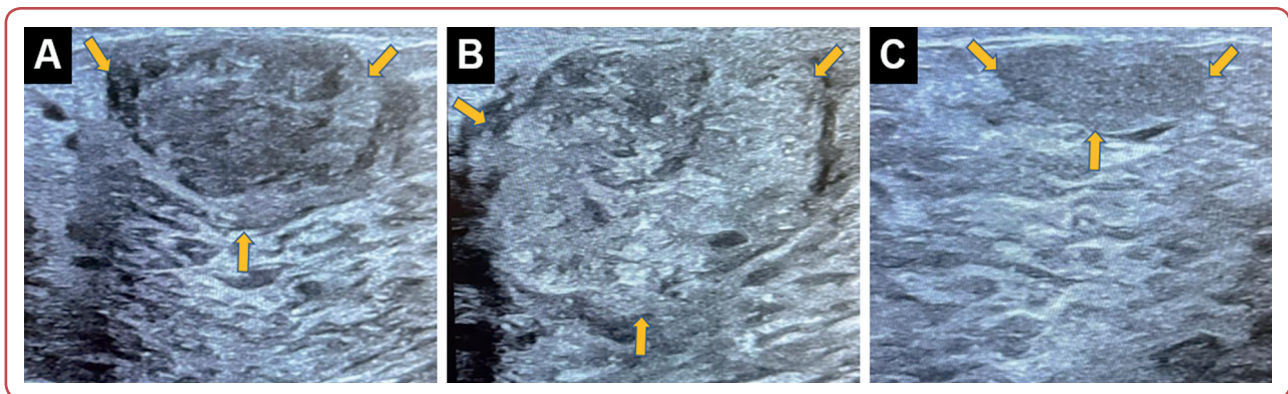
Ultrasound exam of breast showed bilateral heterogenous fibro glandular tissue with hypertrophy of glandular elements Dilated subareolar ducts (physiological). Three soft tissue masses were seen in the left breast; they were oval with lobulated margins and heterogeneous texture; seen at 12, 10 and 7 o'clock, measured about (A) 30.5 x 15.8 mm; (B) 40.9 x 24.2 mm and (C) 18.5 x 7.2 mm; they had no associated posterior acoustic shadowing;
